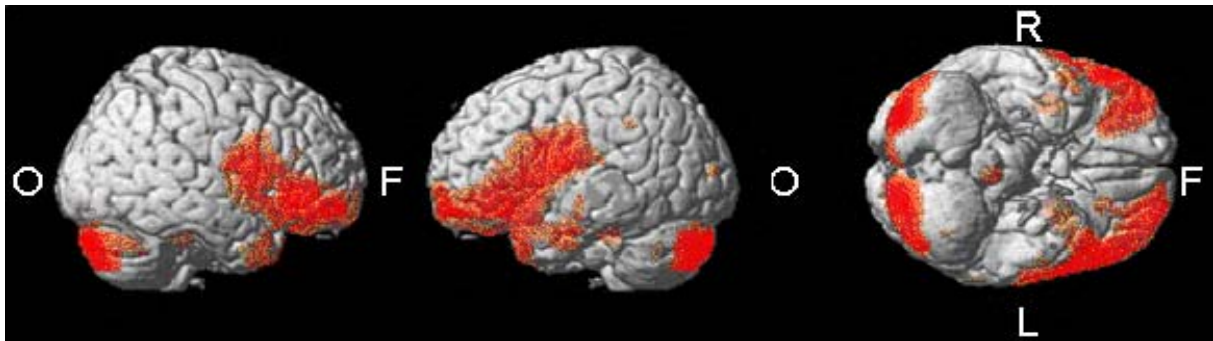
Rendered image of the right lateral, left lateral, and inferior view of the mean activation pattern during maximal distention relative to baseline (C2-C1). Analysis was run at the P uncorrected value of less than .001. The clusters were projected on the cortical surface of a high-resolution-rendered MRI image. F, frontal; O, occipital; L, left; R, right.
